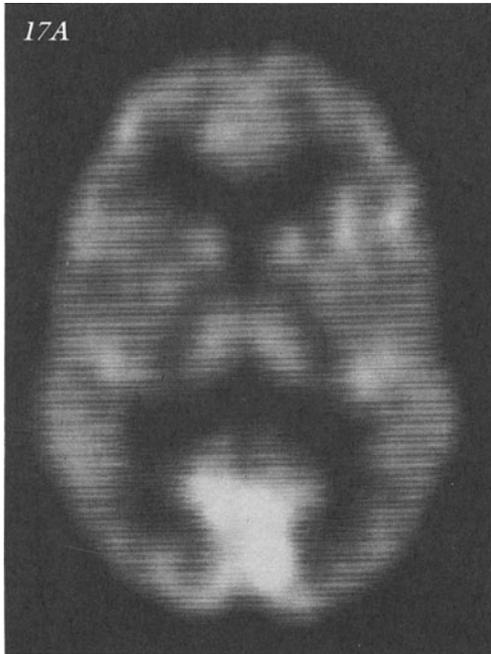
PET scans. The most prominent feature is the increased activity in visual cortex most likely reflecting visual activity during the study. MRI demonstrated mesial temporal sclerosis on the right and this study did demonstrate a possible decrease in activity right temporal area. This 22-year-old female had complex partial seizures since puberty. She had prolonged status epilepticus as an infant related to fever. A) Horizontal, B) sagittal. Courtesy of Dr. Cathy Phillips Neurology University of Massachusetts
